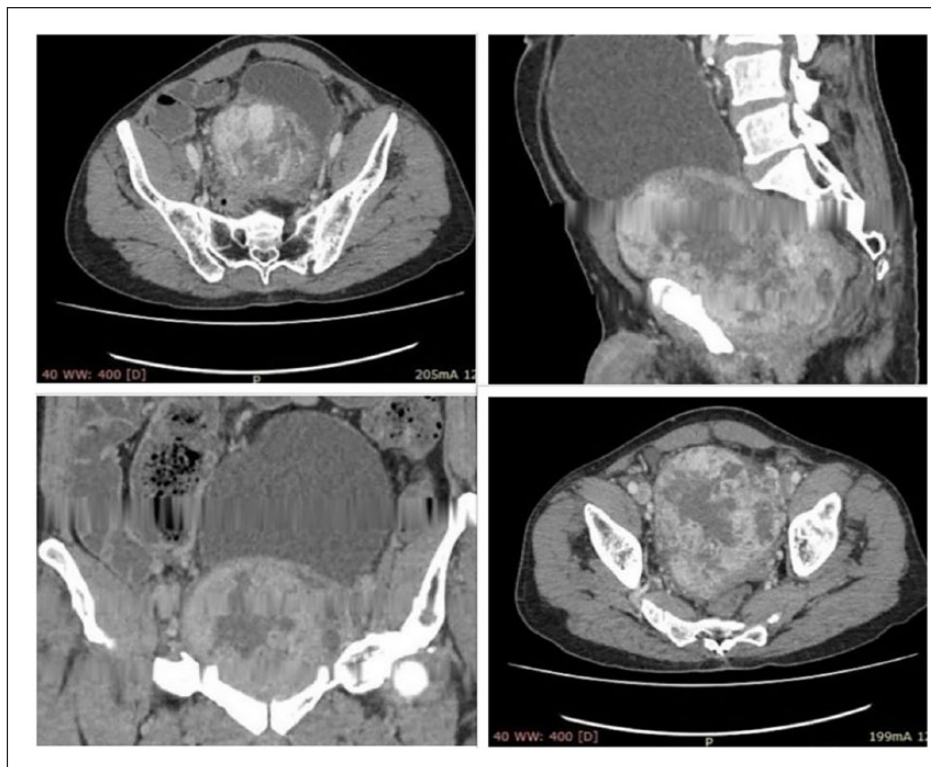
Computed tomography images showing a large mass in the area of the prostate with distended bladder and compressed urethra.
